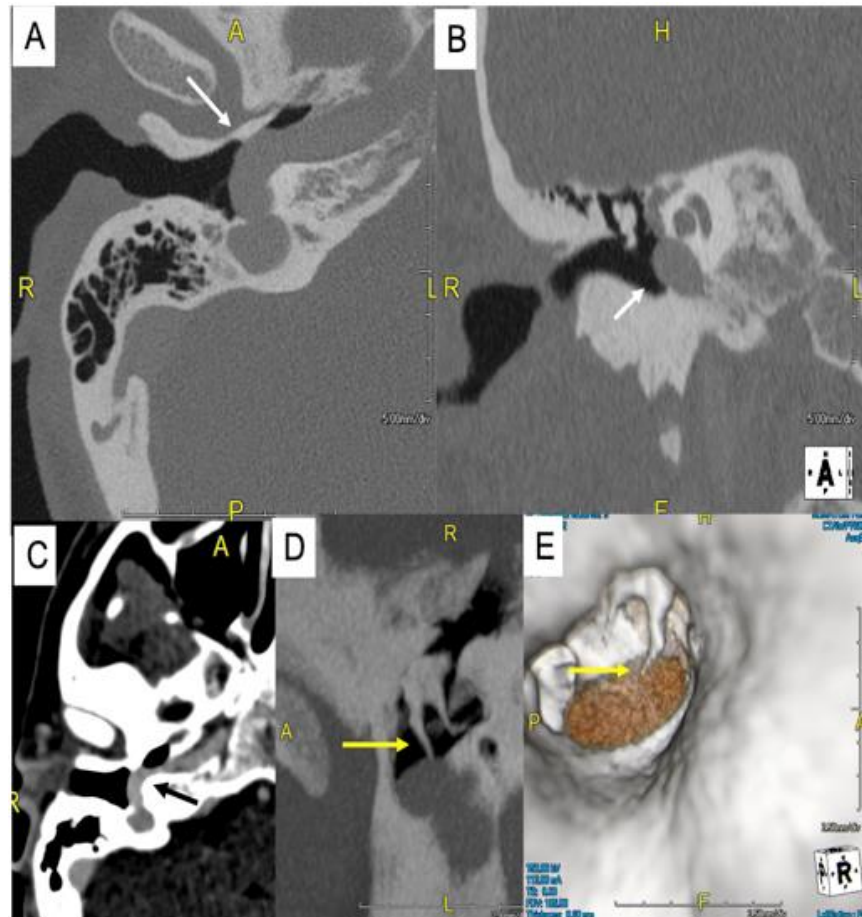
A, B) Axial and coronal CT projections show large vascular structure (white arrows) protruding in the tympanic cavity. C) CTA confirms the vascular nature of the tympanic finding that is consistent with an aberrant petrous segment of the ICA (black arrow). D) MIP and VO reconstructions show the contiguity of the manubrium of malleus and the ICA (yellow arrows).
